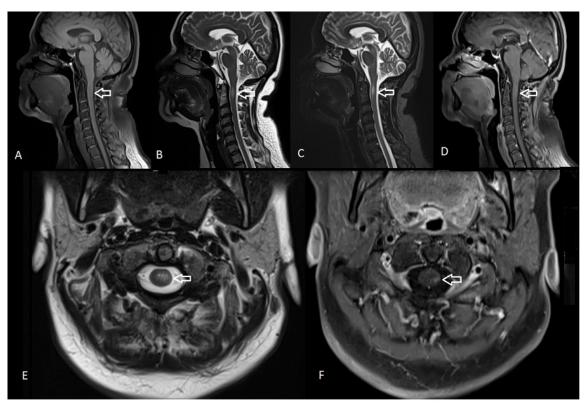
Cerebral and spine MRI. A. Sagittal T1-wigther cervical spine image reveals short segment hypointensity at the level of C2. B and C. Sagittal T2-weighted and STIR images showing short segment hyperintensity. D. Postgadolinium linear enhancement on T1-weighted image. E. Axial T2 showing left lateral intramedullary hyperintensity and (F) punctacte gadolinium enhacement on T1-weighted image.
